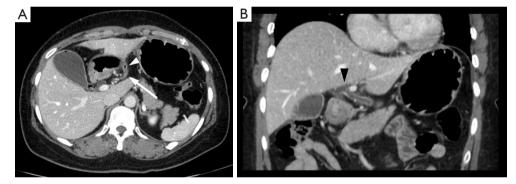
Contrast-enhanced computed tomography of accessory left bile duct draining into the stomach. (A) Axial image of contrast-enhanced computed tomography revealed a tubular structure (white arrow) with an air bubble (white arrowhead). (B) On coronal image of contrast-enhanced computed tomography, a tubular structure was originating from the left hepatic duct (black arrowhead) and extending to the gastric wall.
